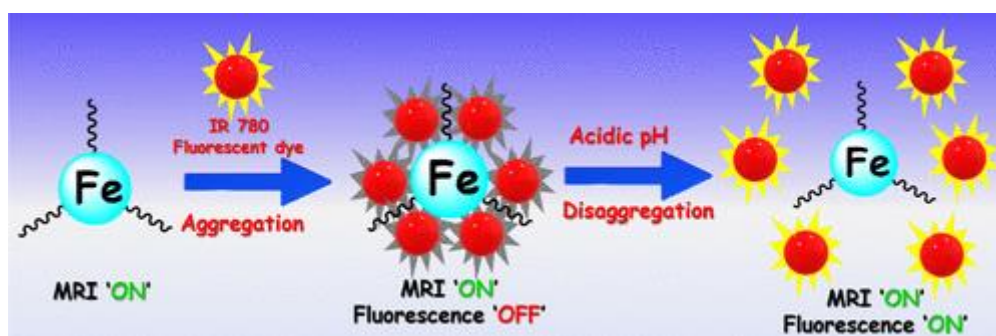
Smart Fe(III)-based MRI probing mechanism for tumor cell imaging..
